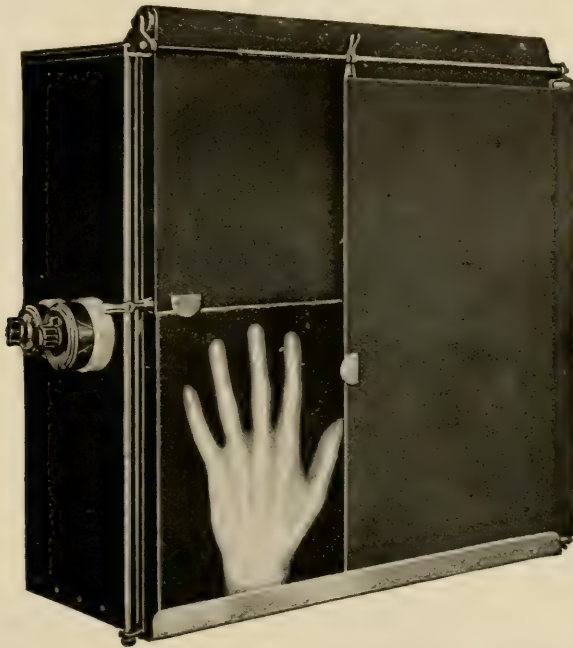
Diagnostic illuminating or view box, for observing X-ray negatives.
